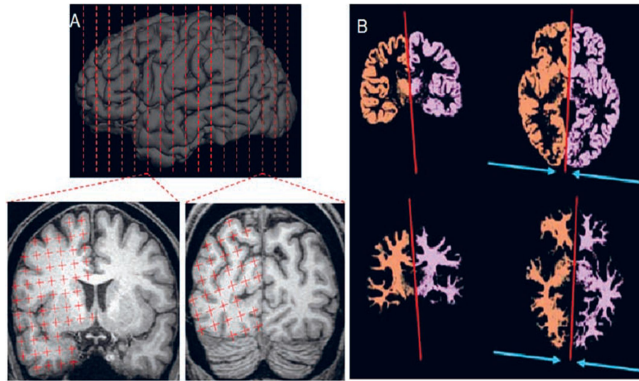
Automatic cerebral hemisphere extraction and volume estimation. T1-weighted axial (left) and T2-weighted sagittal (right) (Manjón and Coupe, 2016; Barrick *et al.*, 2005).
